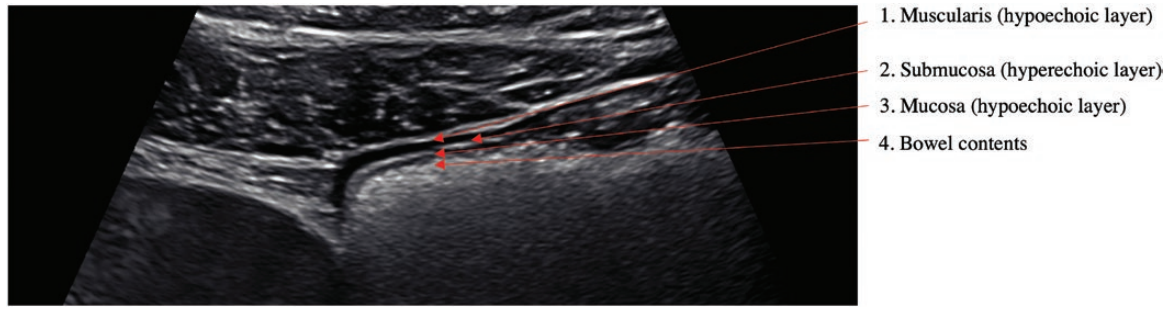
Intestinal ultrasound images demonstrating mural stratification obtained from patients with inflammatory bowel disease using the Canon i700 machine. The image is from the sigmoid colon of Crohn's disease patient in remission. The arrows point to the beginning of each layer moving in an external to internal direction.
